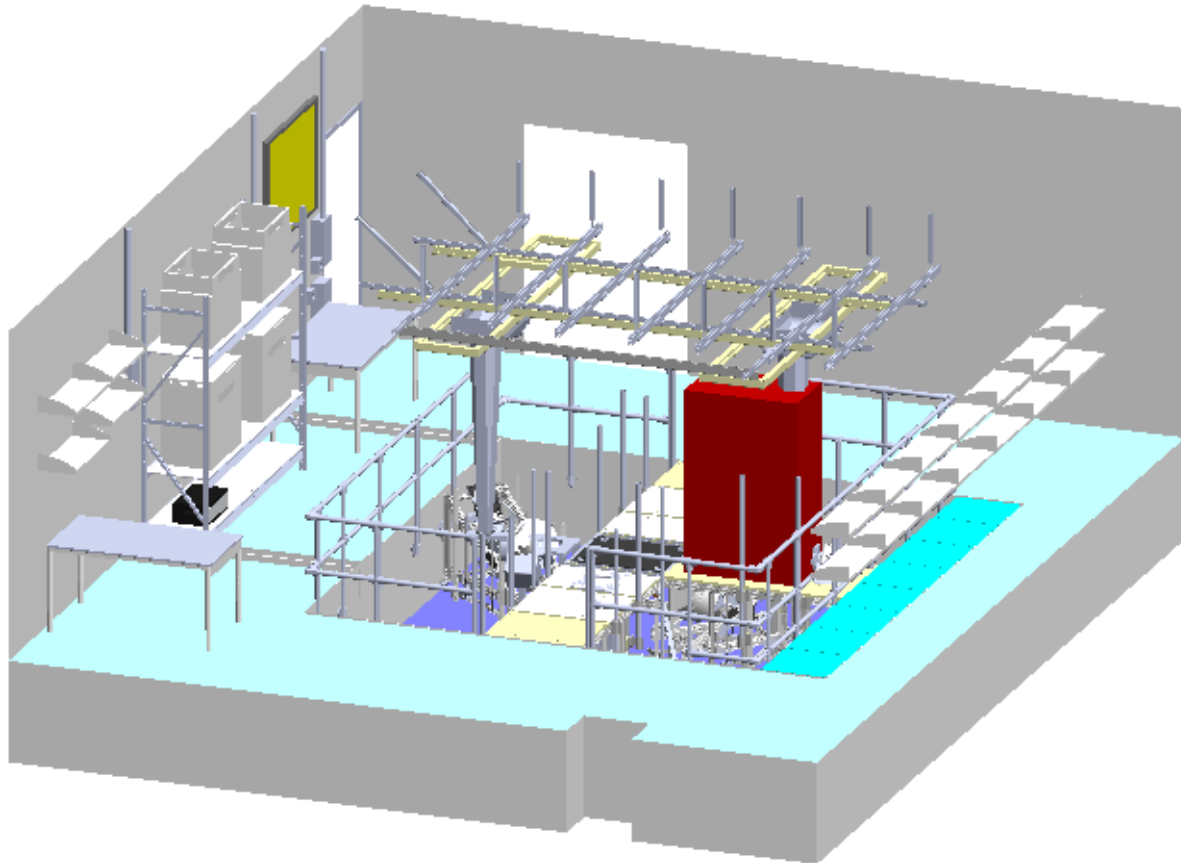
A CAD dimetric view of the biplane fluoroscopy lab, viewing from the south side (north wall visible, yellow board on west wall). This shows a potential setup of the ideal study. The ultrasound machine is depicted as a red box.
